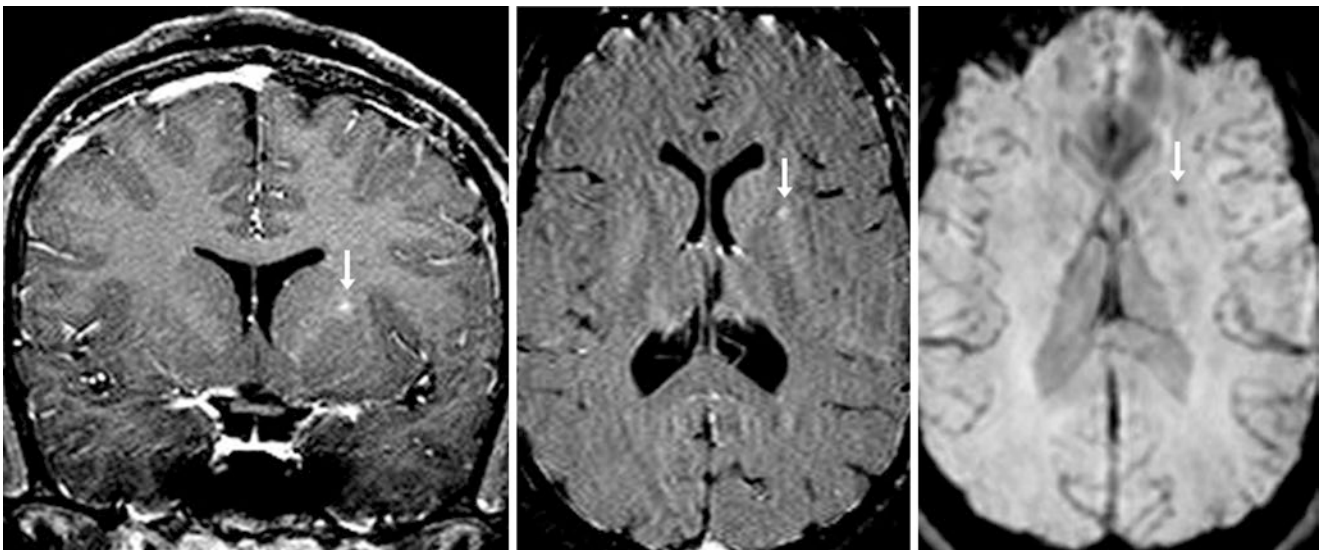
An 11 year old with an unrelated cranial nerve VI palsy underwent an otherwise negative 1.5T MRI on which faint enhancement was demonstrated (arrows) within the left internal capsule on
